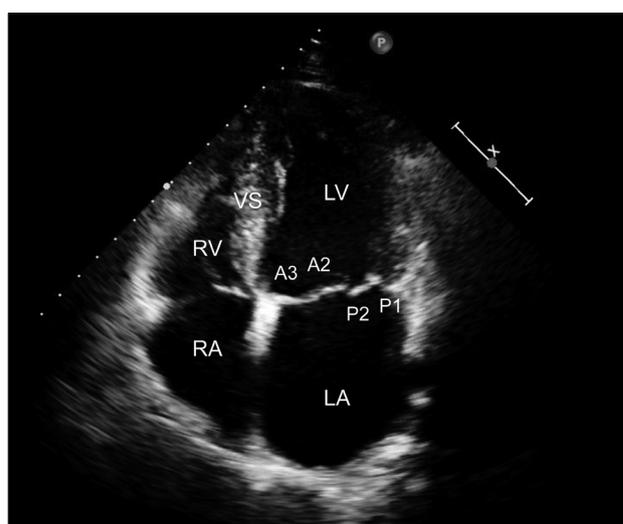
Four chambers apical view by transthoracic echocardiography. Segmental analysis of the mitral valve. LA: left atrium, LV: left ventricle, RA: right atrium, RV: right ventricle, VS: ventricular septum (see also Fig. 5).
